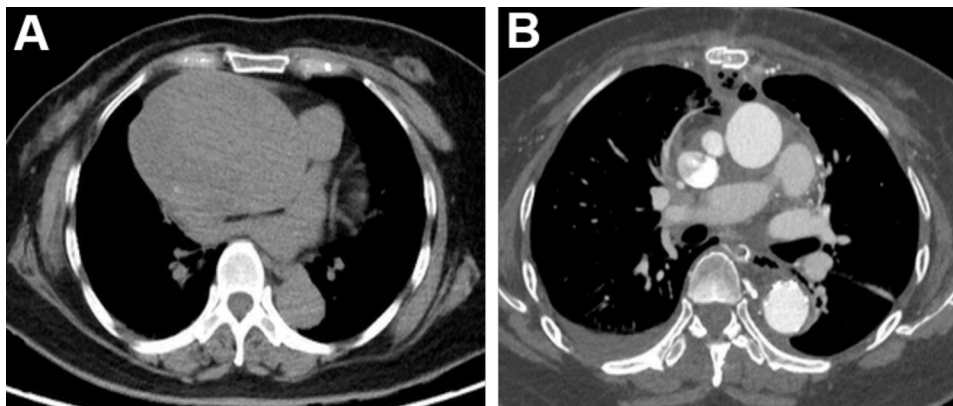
Preoperative and postoperative computed tomography angiography. (A) The ascending aortic aneurysm measured 10 cm, and the tear was localized in the sinus canal junction and near the left subclavian artery. (B) The ascending aortic aneurysm was removed after total aortic arch replacement.
